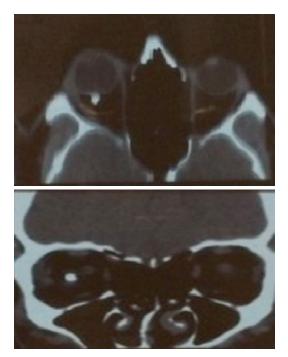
CT scan showing IOFB in the right orbit. (Courtesy: Aditya Jyot Eye Hospital, Mumbai)
